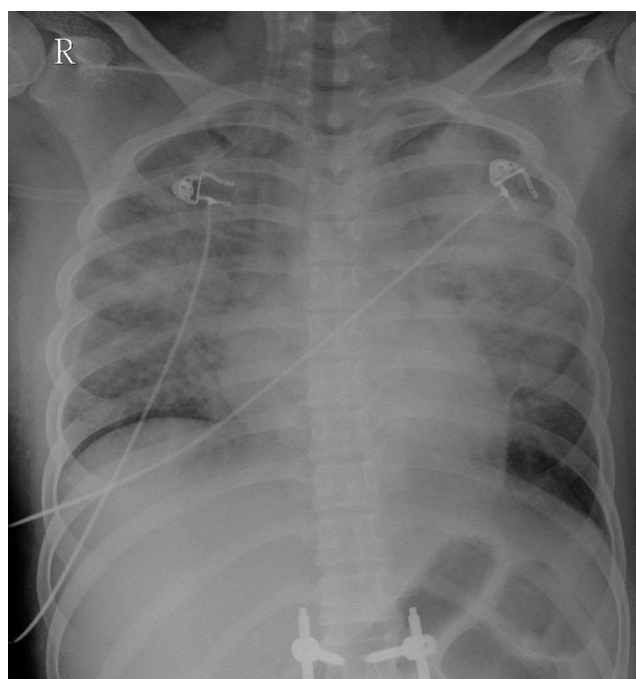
Chest X-ray obtained 51 hours post-injury, showing extensive bilateral diffuse opacities, raising suspicion for ARDS. Abbreviation: R, Right.
